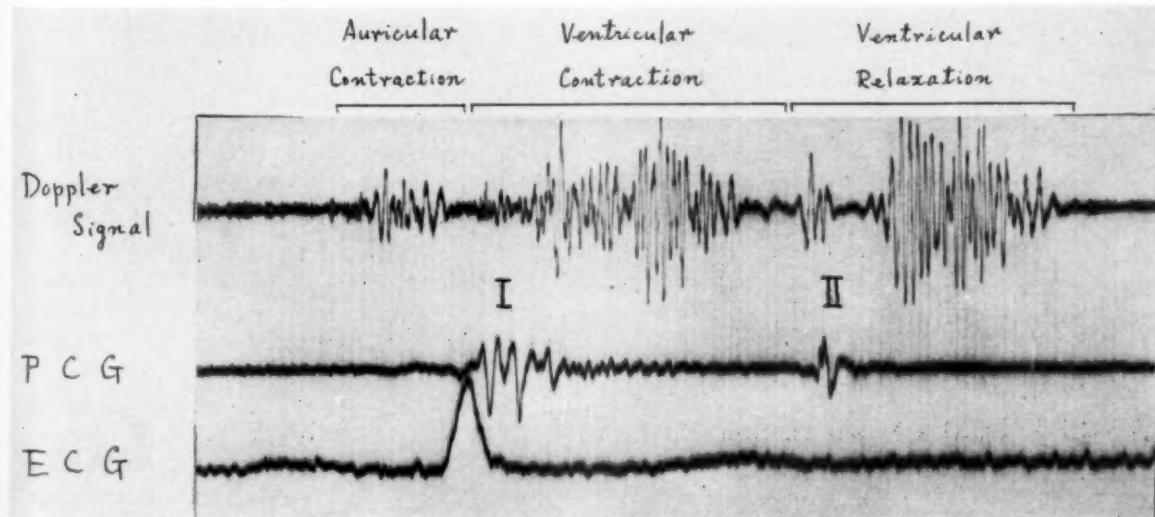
Ultrasonic Doppler signal of low frequency (in the fourth left intercostal space at the parasternal line) related to the movement of the heart wall.
